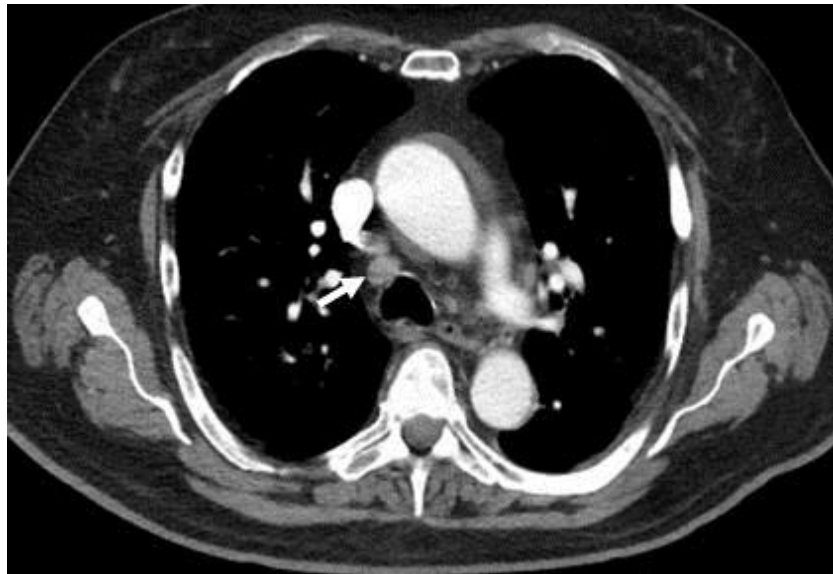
Thoracic CT in soft tissue windows showing lymph node at 4R (arrow).
